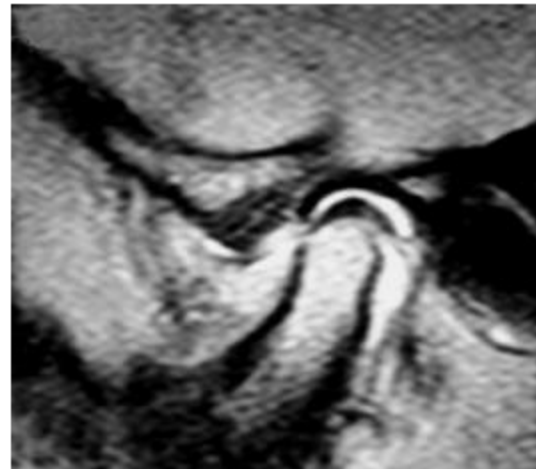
Magnetic resonance imaging T<sub>2</sub> weighted image. It shows effusion of temporomandibular joint in a patient with juvenile idiopathic arthritis
